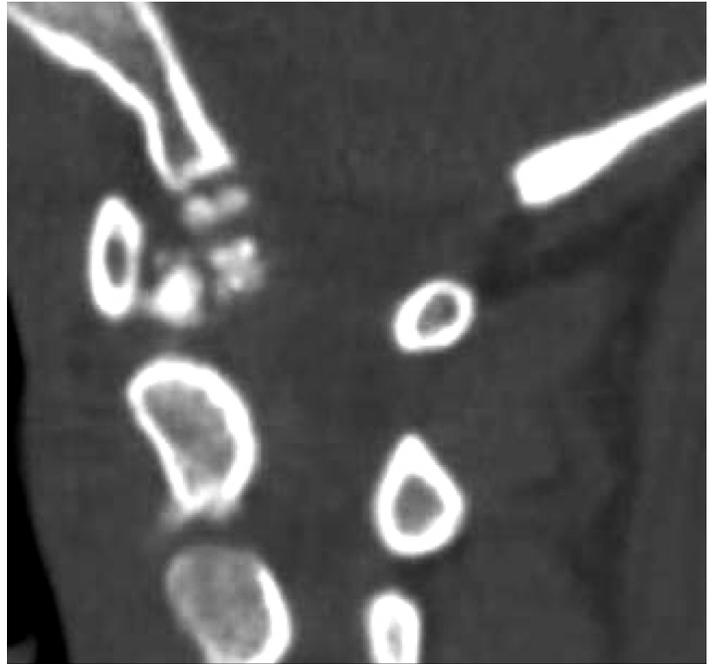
CT scan of cervical spine showing a calcified mass at the transverse ligament at baseline (A) and 2 months later (B).
